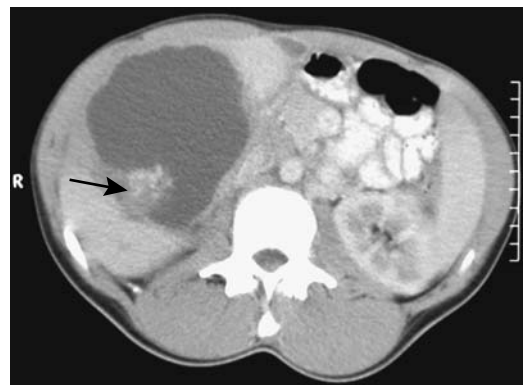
Hydatid cyst. CT also identifies a soft-tissue component within the cyst (arrow). (Courtesy of Algirdas Basevicius, M.D., Kaunas Medical University, Kaunas, Lithuania.)
